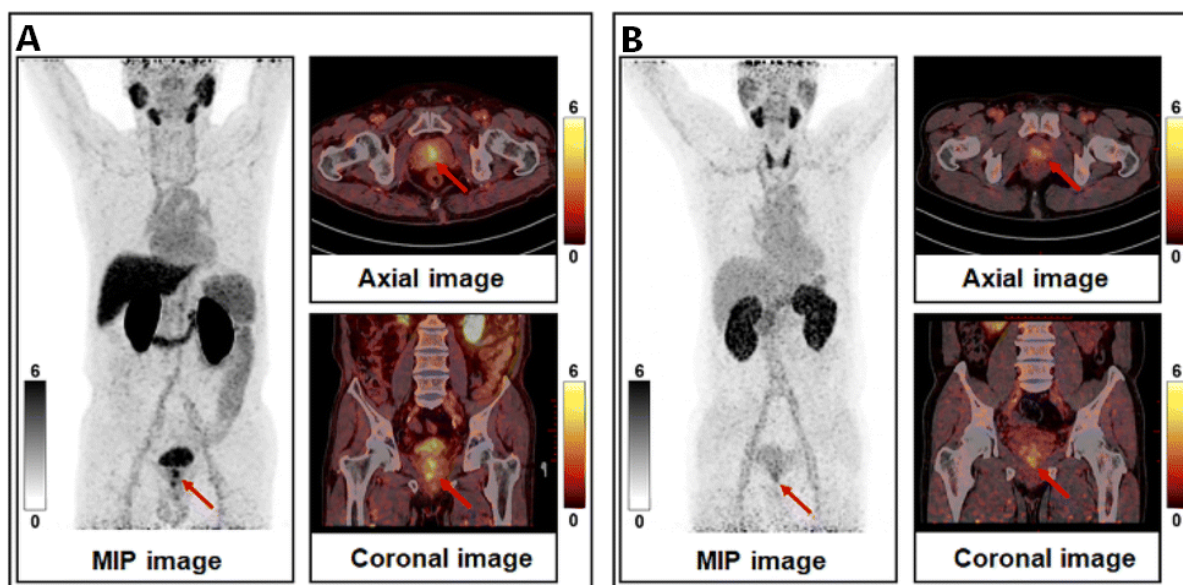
Positron emission tomography (PET) maximum intensity projection (MIP) and corresponding PET/computed tomography (CT) fusion (axial and coronal) of $[^{68}\text{Ga}]\text{Ga-PSMA-FAPI-01}$ (A) and $[^{68}\text{Ga}]\text{Ga-PSMA-FAPI-02}$ (B) at 1 h post-injection are presented. Prostate cancer lesions are marked by red arrows. Reprinted with permission from Hou H *et al.*⁵⁹ Copyright © 2024 Royal Society of Chemistry.
